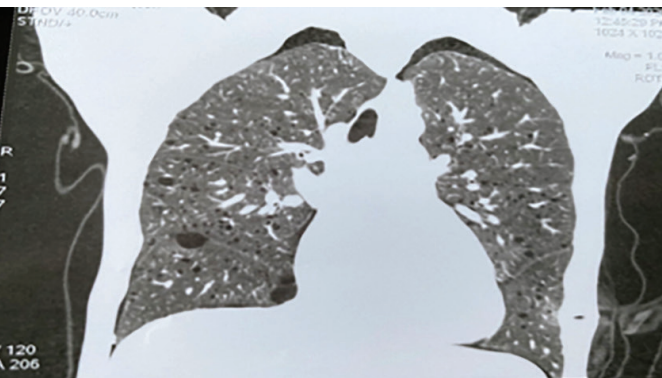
Axial and coronal sections of the HRCT images of the thorax verifying cystic diffuse bilateral lesions in the lung parenchyma
